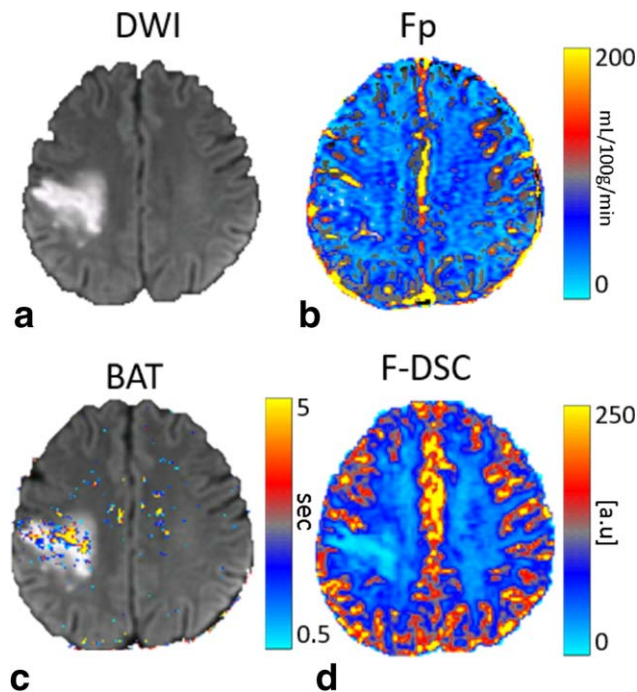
Parameter estimation in stroke. DCE-MRI Fp and BAT maps (B,C) extracted by the ACoPeD tool from a patient following stroke on top of a diffusion-weighted image (A). D: CBF map extracted using DSC-MRI.
